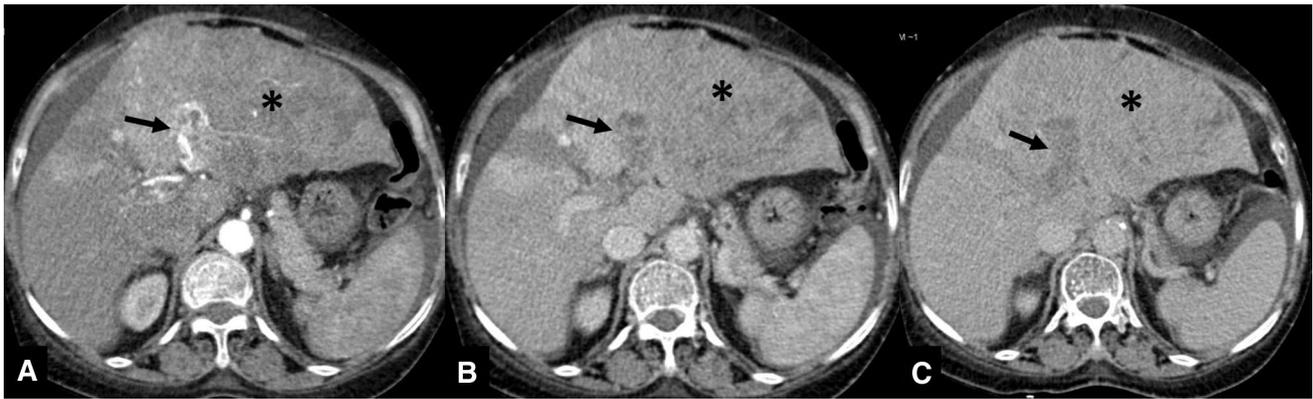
Axial arterial (a), venous (b), and delayed (c) phase contrast-enhanced CT images showing tumor thrombus in the left portal vein (arrow) with an imperceptible lesion in left lobe of liver (asterisk) whose enhancement and washout are difficult to appreciate due to altered perfusion
